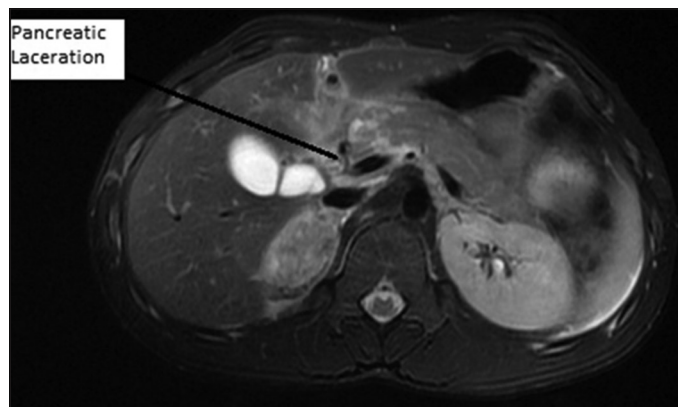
T2-weighted image axial section suggestive of pancreatic laceration on magnetic resonance cholangiopancreatography
